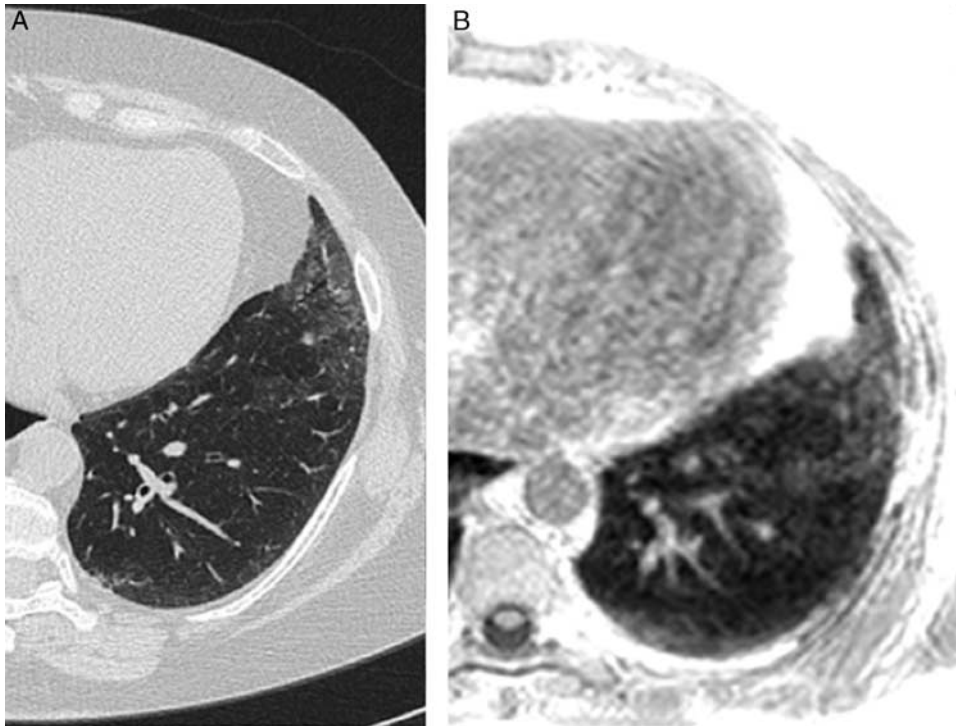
SSc-ILD, left lung: ground-glass opacities on CT and UTE. CT areas of ground-glass opacities (A) may be easily recognized and quantified on UTE (B).
